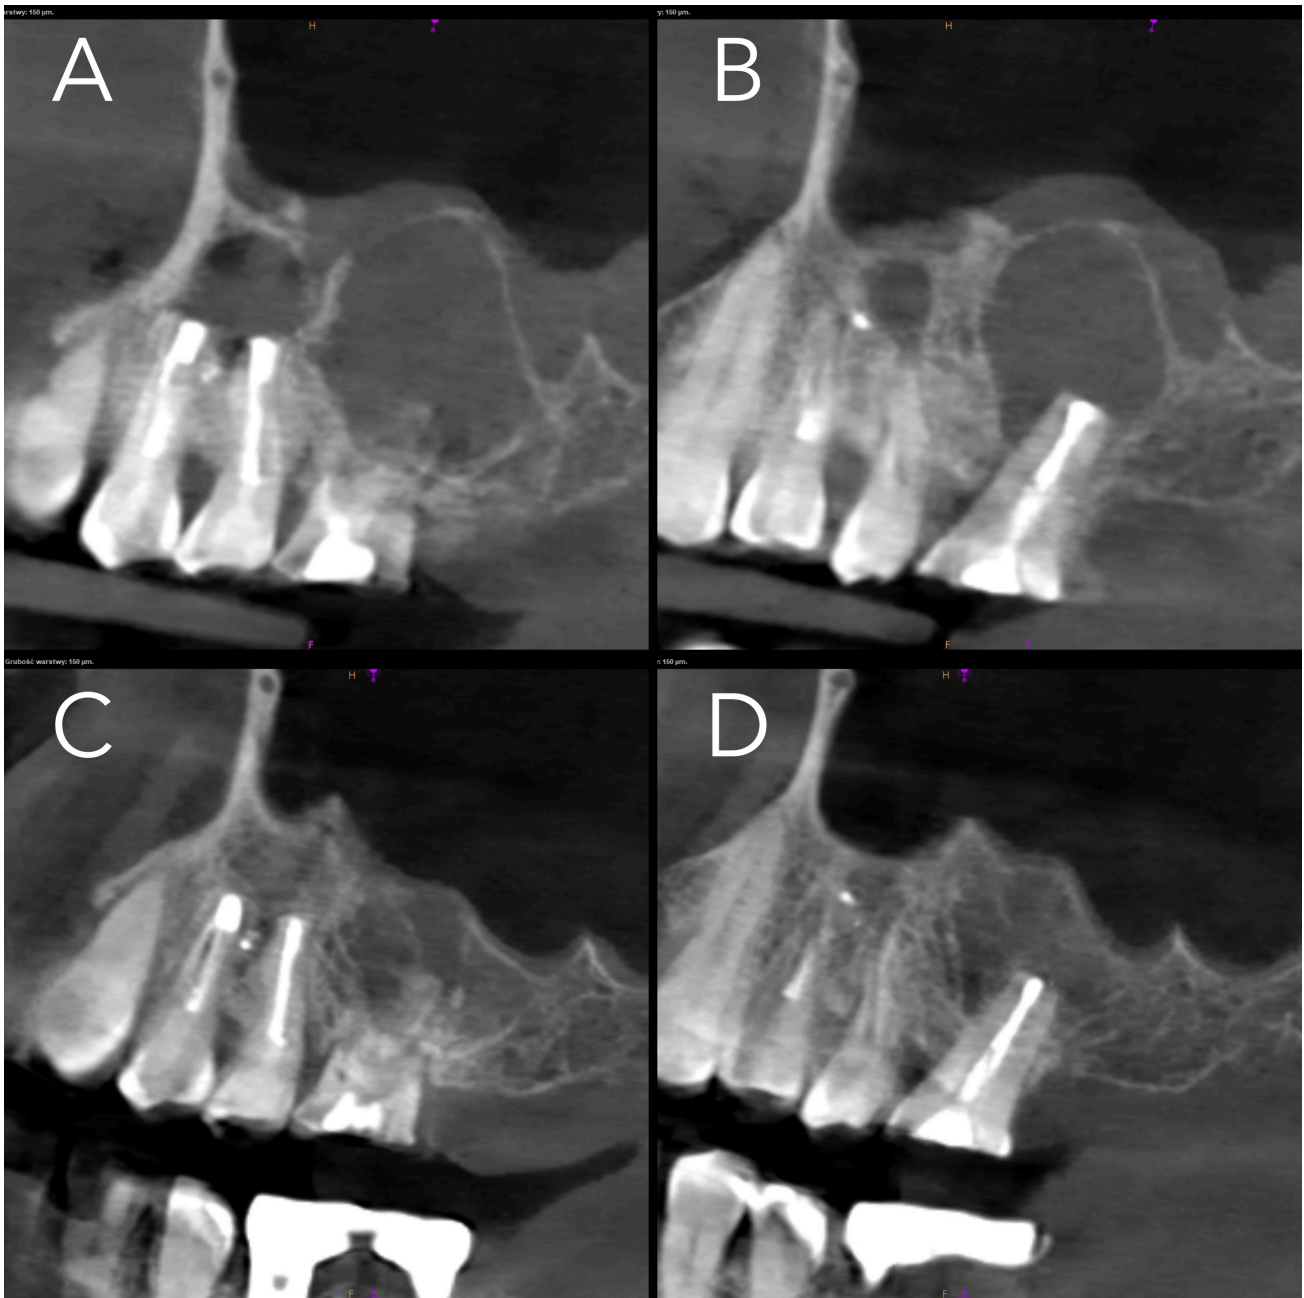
Healing post-op at 8 months. (A) Post-operative CBCT image showing both premolars. (B) Post-operative CBCT image showing the palatal root of the first molar. (C) 8-month CBCT follow-up: healing around the premolars is visible. (D) 8-month CBCT follow-up: healing around the palatal root is visible.
